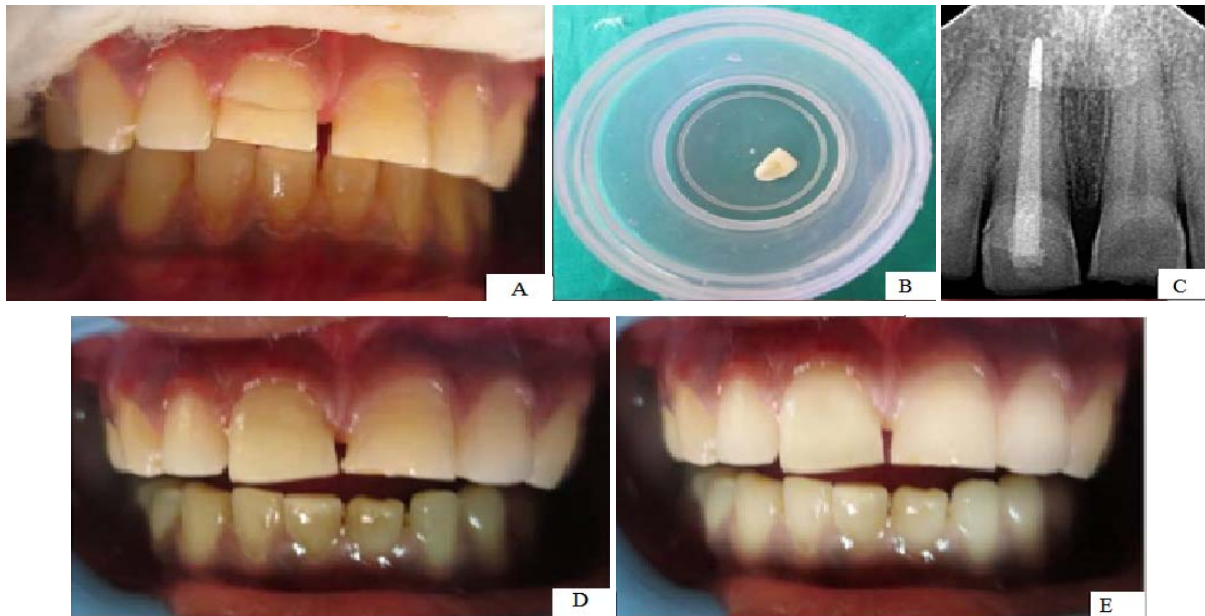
(A) Pre-operative view; (B) Pre-operative Intraoral peri-apical radiograph; (C) Tooth with gingivectomy and in place of fiber post; (D) Intraoral periapical radiograph showing reattached fragment; (E) Post-operative view; (F) 2 year follow up
